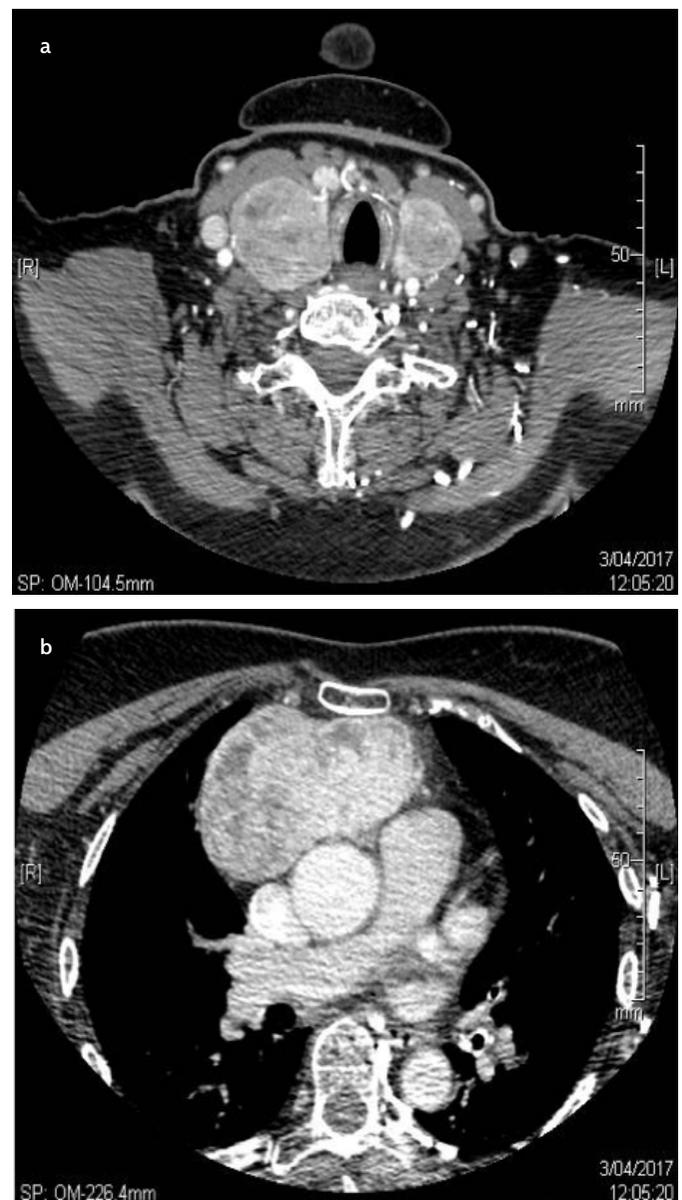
a, b. CT of the neck showing a massive diving goiter in the anterior mediastinum. CT, computed tomography
